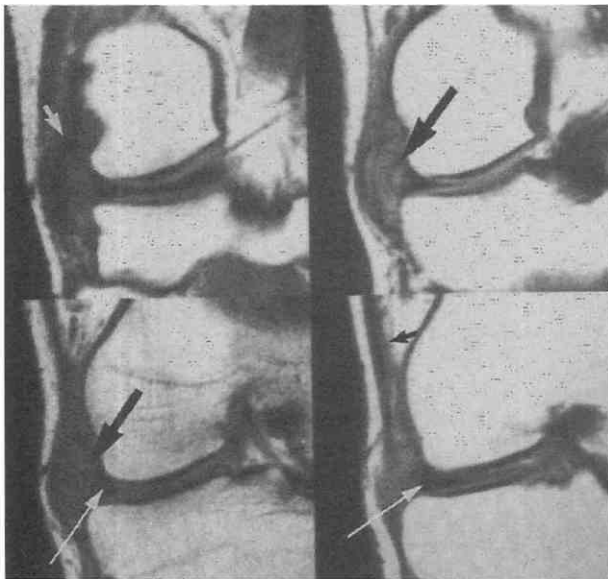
Lateral meniscal cyst. Coronal T1-weighted images show a small lateral meniscal cyst (*large black arrow*) and an associated meniscal tear (*large white arrow*). Note the relative containment by the fibular collateral ligament (*small white arrow*) and the iliotibial band (*small black arrow*).
